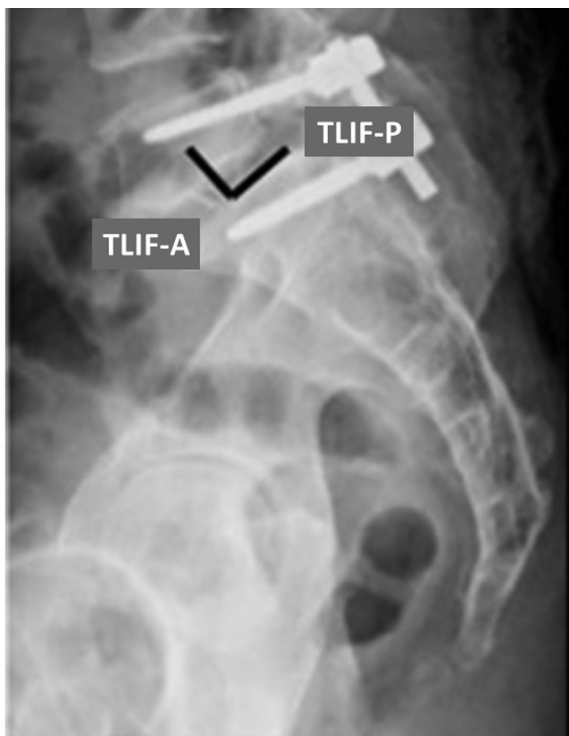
Lateral spine radiograph demonstrating the criterium for cage positioning at the intervertebral space. TLIF-A, transforaminal lumbar interbody fusion with an anterior cage; TLIF-P, transforaminal lumbar interbody fusion with a posterior cage.
